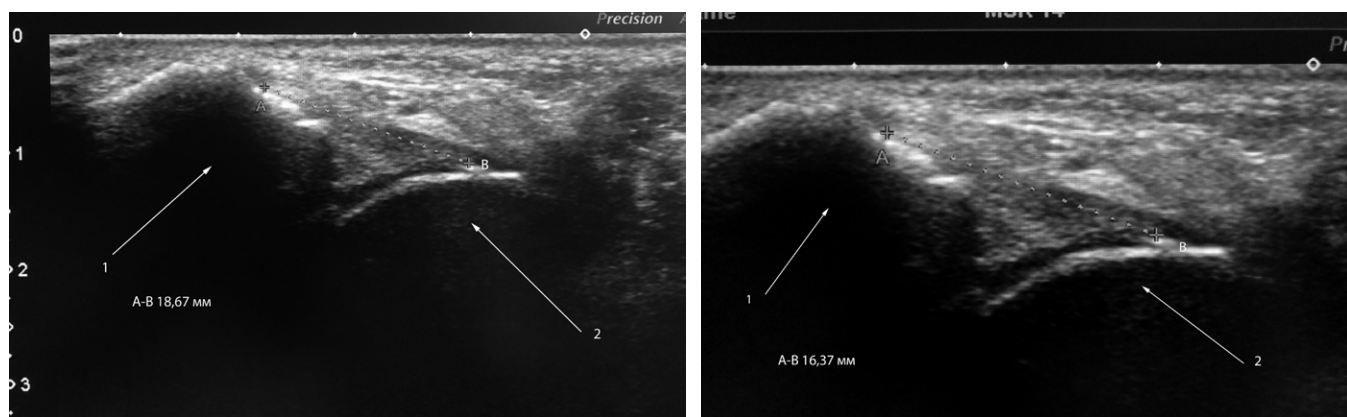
Length measurement of the anterior talus-fibular ligament (ATFL) in a neutral position during sonography.
